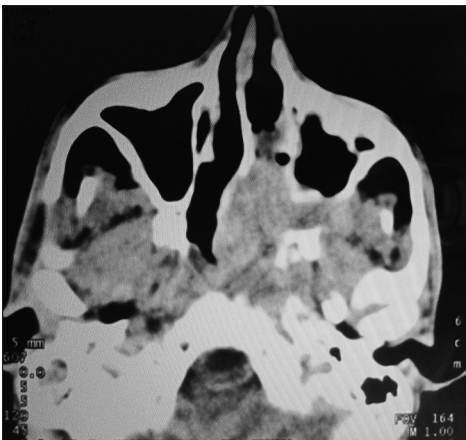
Computed tomography scan showing left nasopharyngeal carcinoma
